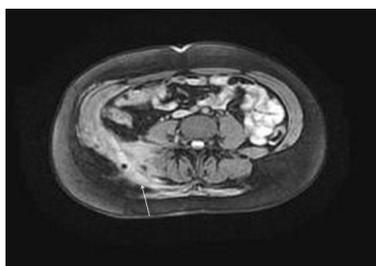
A 30-year-old female with a 3-year history of Crohn's disease of the terminal ileum. Axial MRI (GE Echospeed 1.5 T HD), T1 post-gadolinium (MultiHance) demonstrates an abscess in the right retroperitoneal and para-vertebral space with enhancement of the walls.
